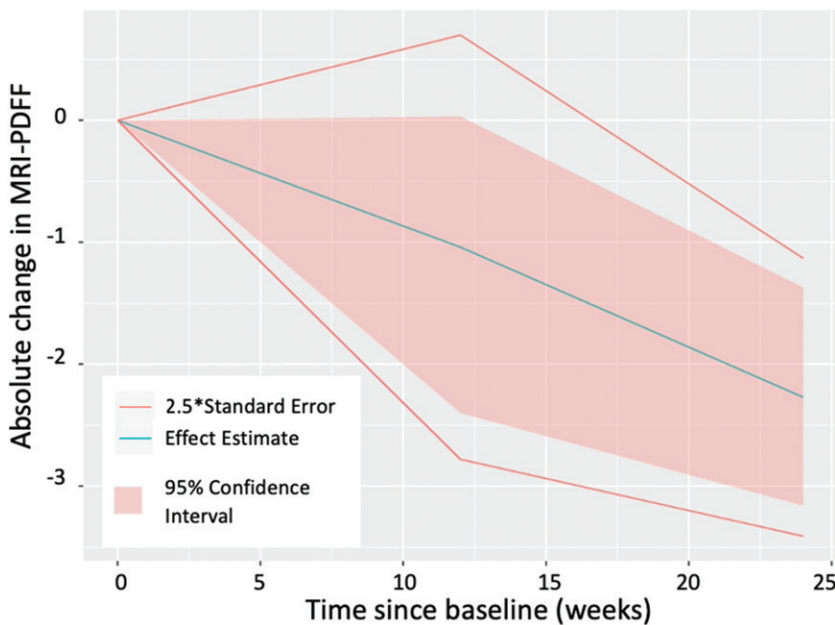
Line graph shows absolute change in MRI proton density fat fraction (PDFF) as a function of duration of placebo treatment (weeks) for our repeated-measures linear mixed-effects model, which estimates a mean absolute reduction in baseline MRI PDFF of 2.3 units after 24 weeks of placebo treatment.
